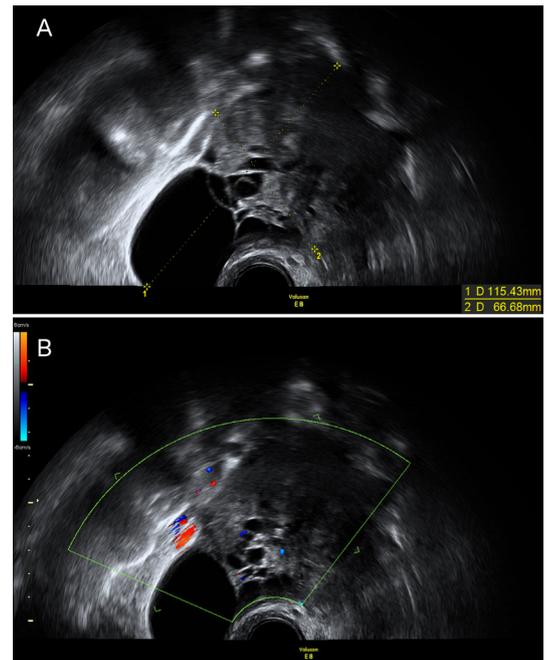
Transvaginal ultrasound showing a complex mass in the right adnexal area measuring 115 mm×66 mm, with both solid and cystic components (A) and low vascularity in colour Doppler evaluation (B).
